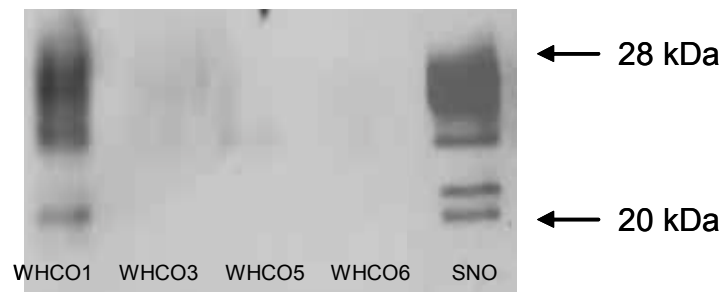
The MUC1 CT is present in nuclear extracts of WHCO1, WHCO5 and SNO. Nuclear protein was resolved using 12.5% SDS-PAGE prior to transferring to nitrocellulose and then immunoblotting with CT2 (anti-MUC1 CT antibody). The banding pattern in lanes representative of WHCO1 and SNO nuclear extracts is typical for this antibody (personal communication - Dr Gendler's laboratory, Li *et al.*, 2003a).
